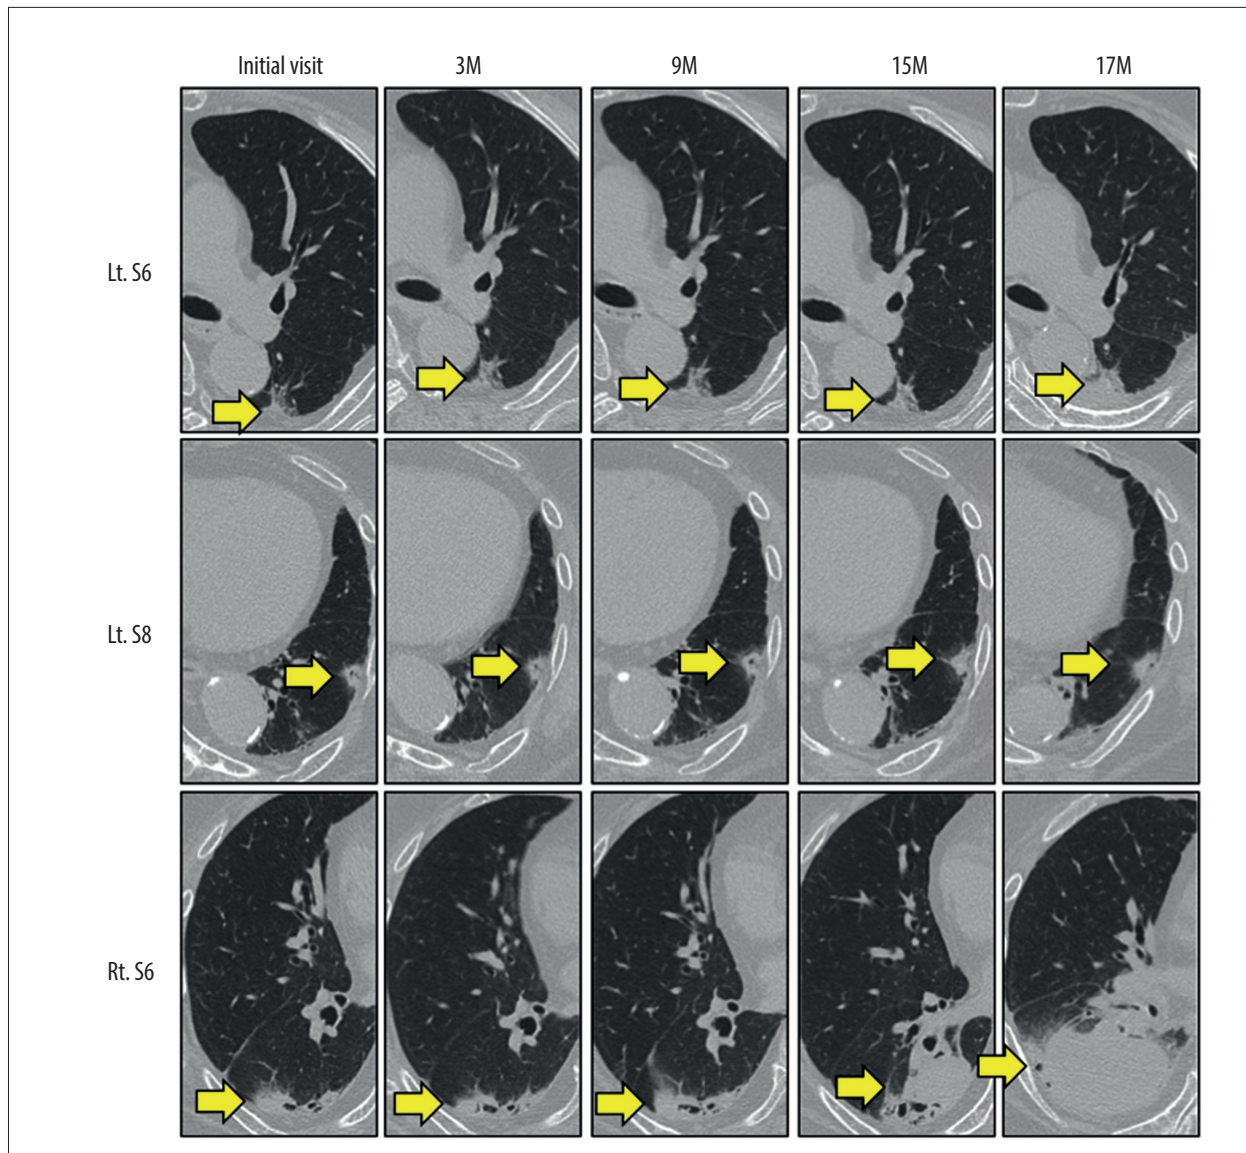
Chest CT findings in the longitudinal follow-up. A chest CT on the patient's initial visit demonstrated 3 subsolid nodules in the lung fields: a 9-mm subsolid nodule in the superior (S6) segment of the left lower lobe (upper left panel), an 8-mm subsolid nodule in the anteromedial (S8) segment of the left lower lobe (middle left panel), and an 11-mm subsolid nodule in the superior (S6) segment of the right lower lobe (lower left panel). The mass lesion in the right S6 segment had grown from 11 mm to 37 mm at 15 months. The mass in the right S6 segment grew from 37 mm to 60 mm within 1 month. The subsolid nodules in the left S6 and S8 segments were unchanged in size through the clinical course.
